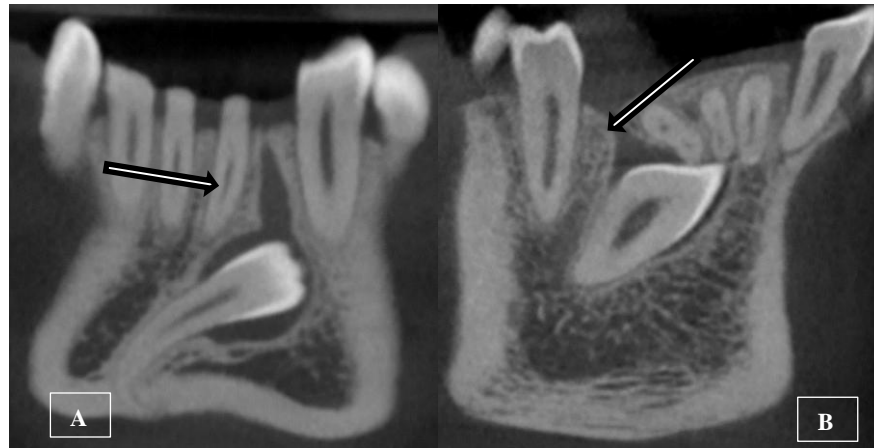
A. CBCT image of coronal sections (slice thickness 150  $\mu$ m) showing gubernacular canal (marked by arrow) in lower right mandibular lateral incisor teeth
